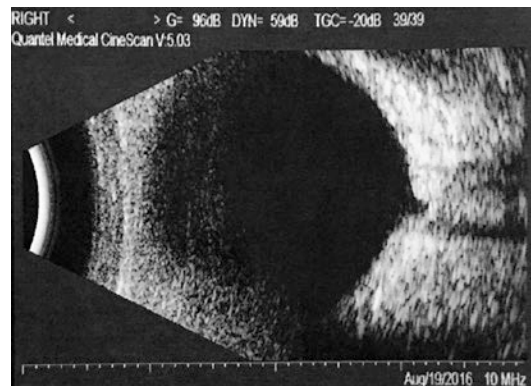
B-scan ultrasonography in ocular chemical burns revealed abnormality of cup-to-disc ratio of the optic nerve head
